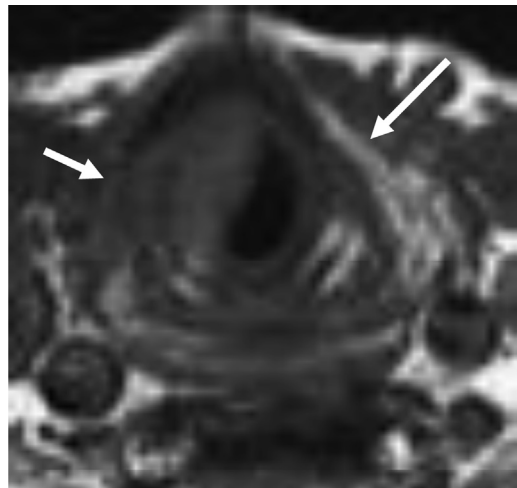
MR imaging of cartilage invasion. Axial non-contrast T1W sequence was obtained through the thyroid cartilage in a patient with an SCCA of the right true vocal cord. Note the normal high T1W signal within the thyroid cartilage on the left side (*long arrow*) but replacement of the T1W (*short arrow*) adjacent to the tumor. The replacement of the normal T1W signal could be either due to tumoral invasion or peritumoral inflammation.
